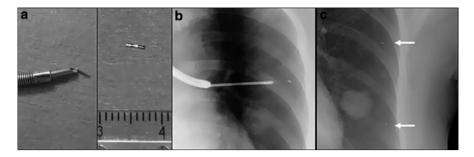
(a) *Left*: Size comparison of an iridium marker and the tip of a large-diameter biopsy needle. *Right*: iridium marker with ruler of millimeter gradations. (b) X-ray image of bronchoscopic placement of an iridium marker in the lung. (c) X-ray image after placement of two iridium markers. The *white arrows* mark their positions
